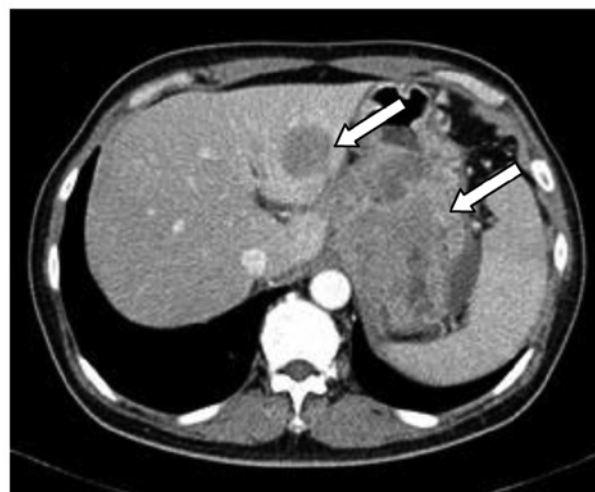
The initial CT scans of the abdomen revealed an irregular mass with perigastric infiltration in the stomach and a metastatic mass in the liver (arrows). CT, computed tomography.
